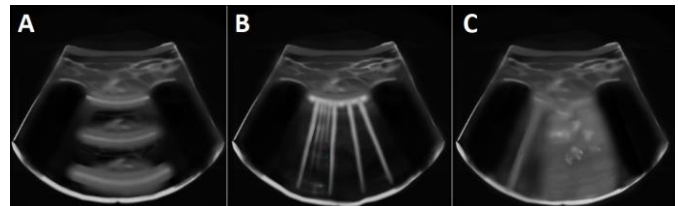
Images of lung ultrasonography. From the top-to-bottom of each image: skin layer, the muscle layer, and a hyperechoic pleural line on the edge of the lung surface. A) A-lines image. Health lung. B) B-lines image. Lung with water (more B-lines mean more parenchymal water). C) Lung consolidation image. Loss of pleural line continuity, coalescent B-lines and hyperechoic air bronchograms in consolidation areas can be seen in deflated lungs. Source: Graphic representation prepared by the authors.
